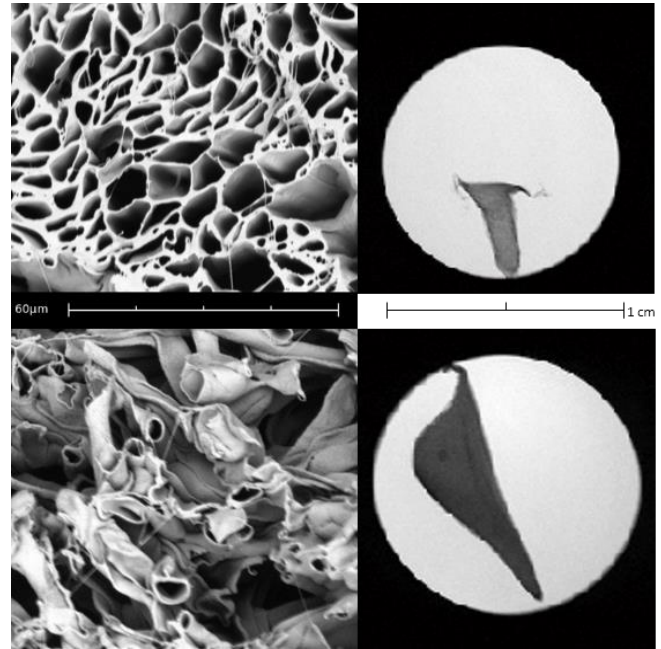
Aligned fibers (top) and random fibers (bottom) are shown alongside the MR image of the cross section of each fiber immersed in cyclohexane.
